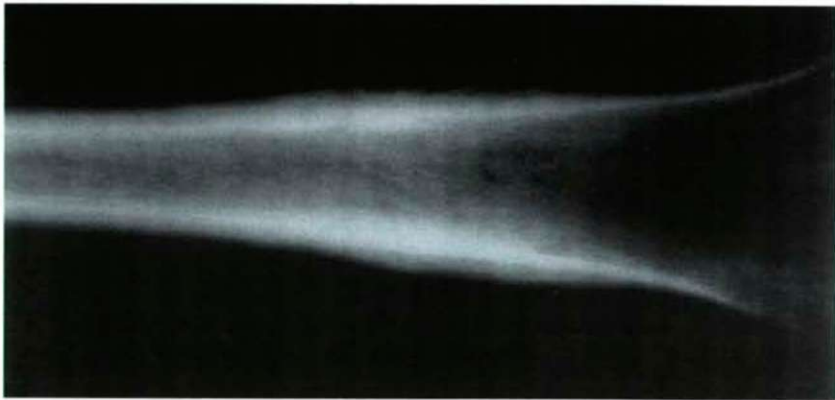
AP radiograph of the right femur showing cortical thickening with periostitis (X-ray by M. PANUEL).
